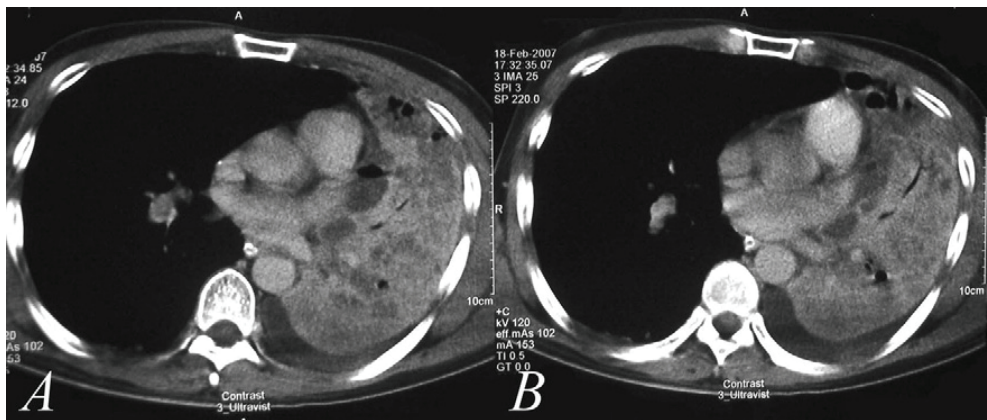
Computed tomography scan of the lung showed multiple low-density regions with marked consolidation as well as some parapneumonic effusions. The contralateral lung is spared. The involved hemithorax is smaller in volume while the spared hemithorax expands normally.
